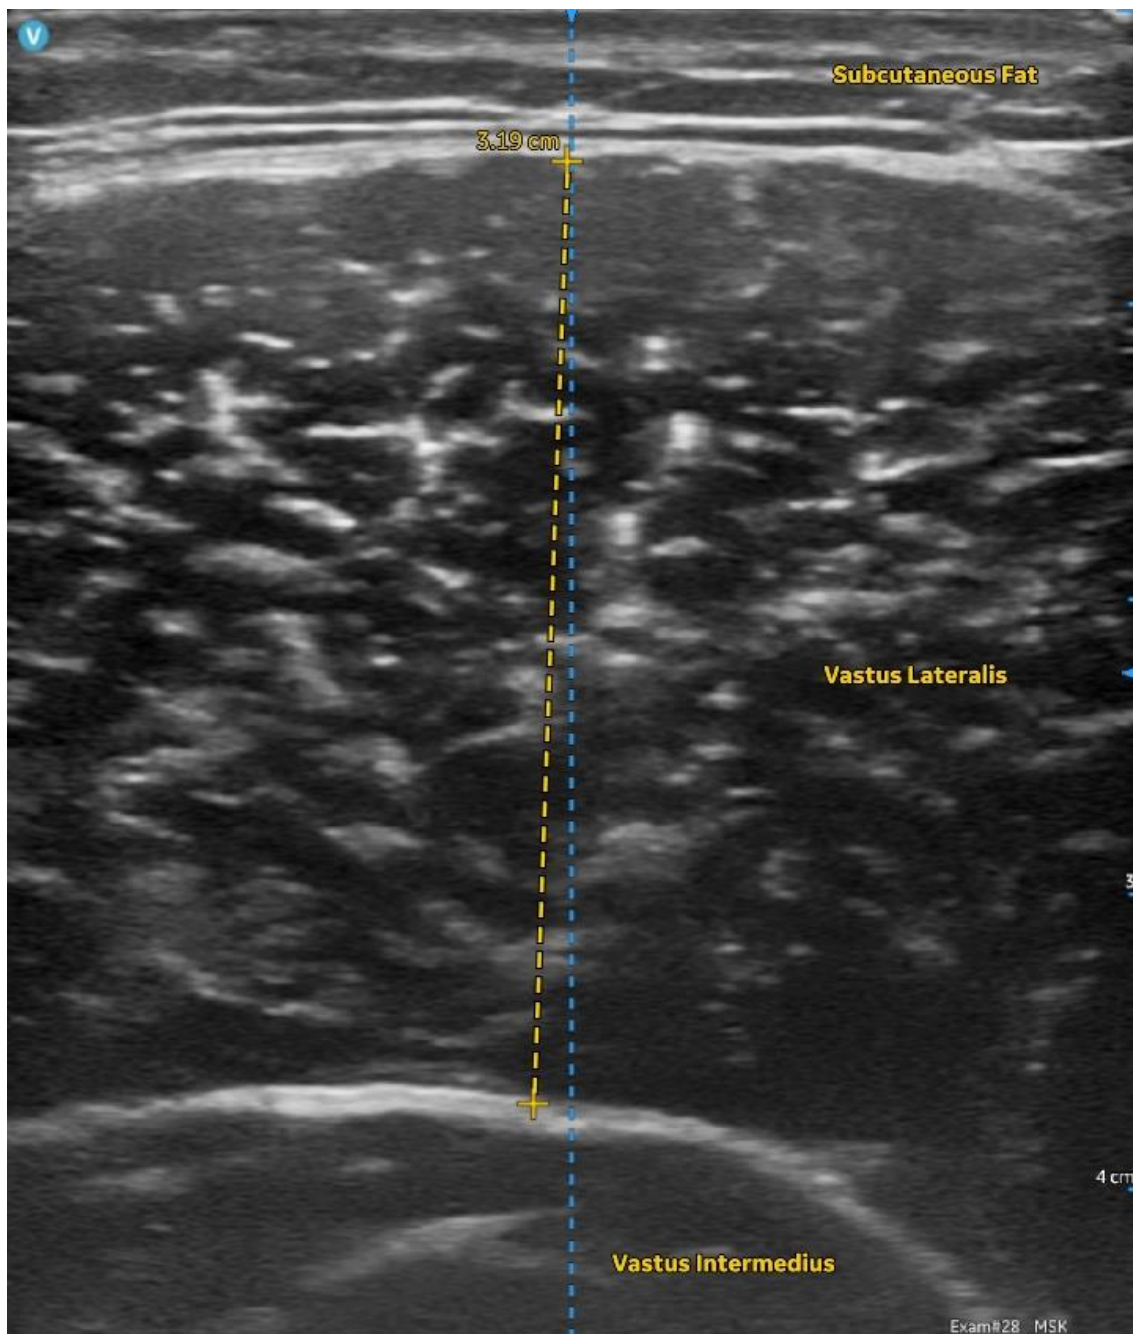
Example of ultrasound measurement of Vastus Lateralis muscle thickness (VLMT) in the transverse plane.
